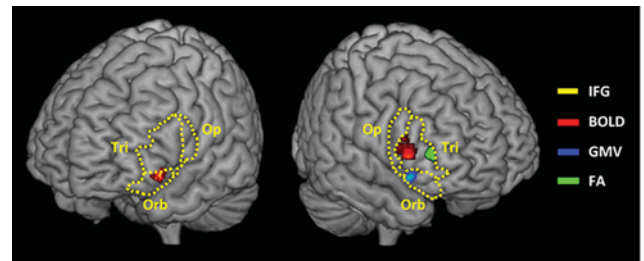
Cluster maxima of the plastic modifications induced by the inhibitory control training in magnetic resonance imaging blood oxygen level dependent signal (BOLD, red), grey matter volume (GMV, blue) and white matter fractional anisotropy (FA, green). The left and right inferior frontal gyri (IFG, dotted yellow lines), pars opercularis (Op.), triangularis (Tri.) and orbitalis (Orb.) are represented.
